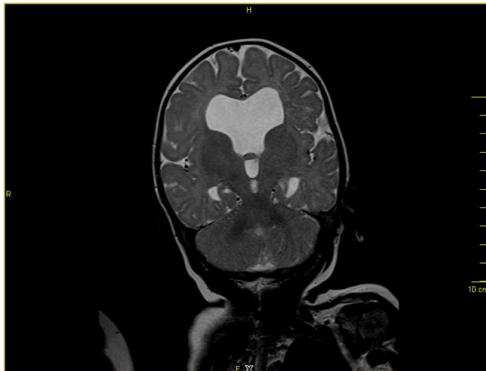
Coronal MR image (T2 Weighted) showing fusion of frontal horns of both lateral ventricles, wide communication of the fused segment with the 3rd ventricle and absent septum pellucidum.
